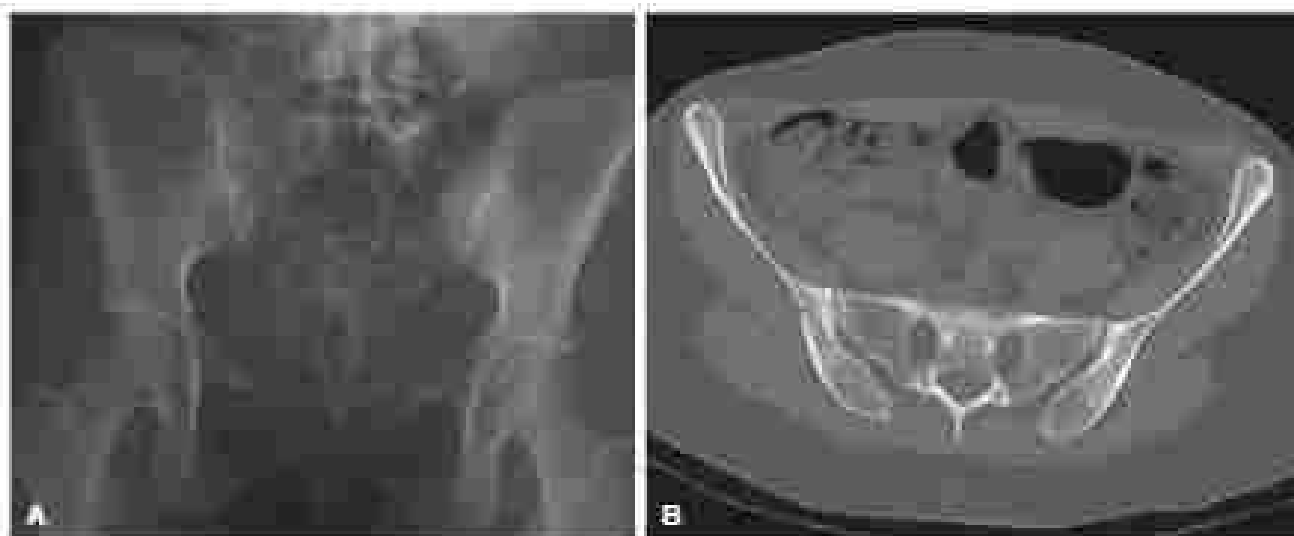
(A) Anteroposterior radiograph of stable minimally displaced lateral compression pelvic fractures. (B) Axial computed tomography image of the pelvis shows bilateral lateral compression fractures.
